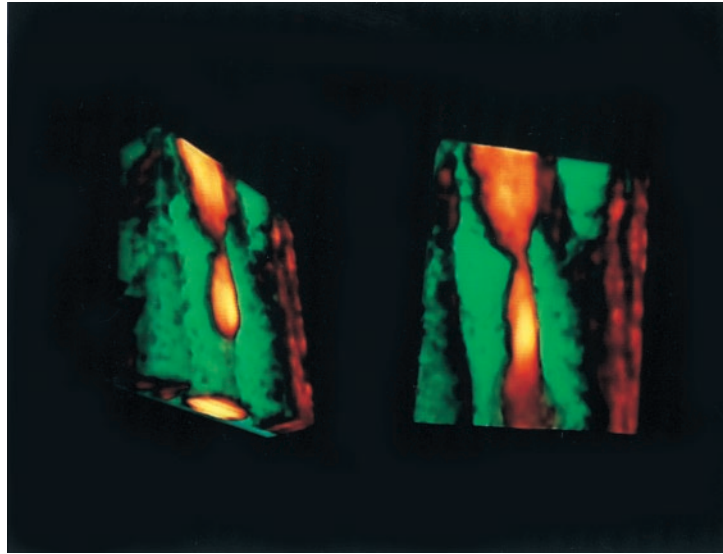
Volume rendering of high-grade carotid stenosis. Data were acquired with 6-DOF scanhead tracking. Irregularly sampled power Doppler images served as raw data for the reconstruction. Note the excellent definition of stenosis and the surrounding weakly echogenic plaque material, color-coded in green. The vessel walls of the carotid artery are well delineated.
